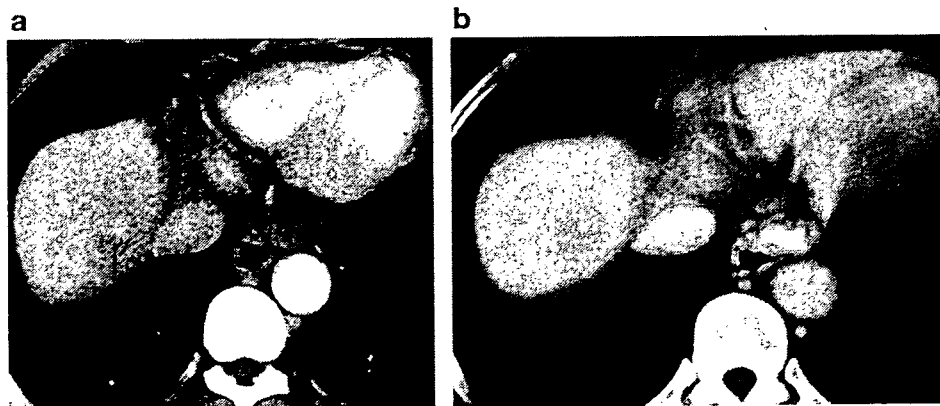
Multiphase CT obtained 2 months prior to transplantation of a patient with chronic hepatitis B demonstrates the nodule-in-nodule enhancement pattern that is characteristic of classic HCC developing within an early HCC or a dysplastic nodule. a Faint
